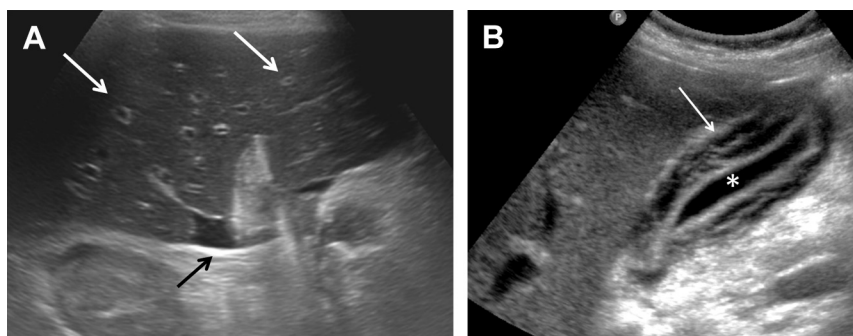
Acute hepatitis: ultrasonography. (A) A 29-year-old man with acute hepatitis. There is increased prominence of the periportal echoes caused by periportal edema (white arrows), and a small amount of perihepatic ascites fluid (black arrow). (B) There is marked thickening and edema of the gallbladder wall (white arrow). The gallbladder lumen is collapsed (asterisk), helping to distinguish it from acute cholecystitis.
